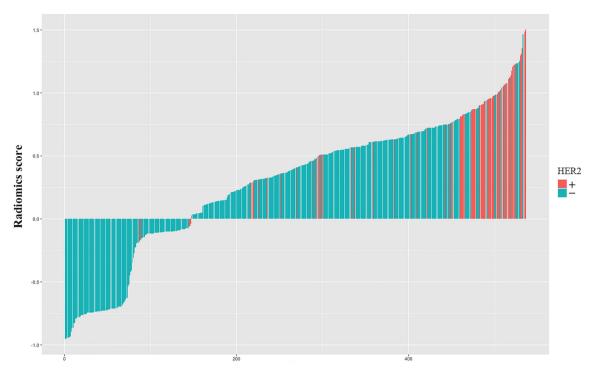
Radiomics score for each patient in the entire cohort. CT, computed tomography; HER2, human epidermal growth factor receptor 2.
